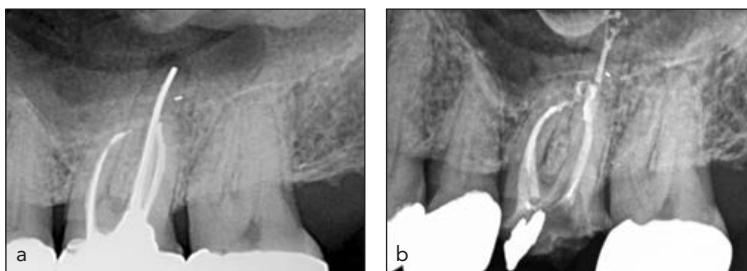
Preoperative (a) and postoperative (b) radiographs of a retreatment procedure on a tooth initially obturated with silver points. Bypassing and the Masserann technique were implemented to remove the points.
